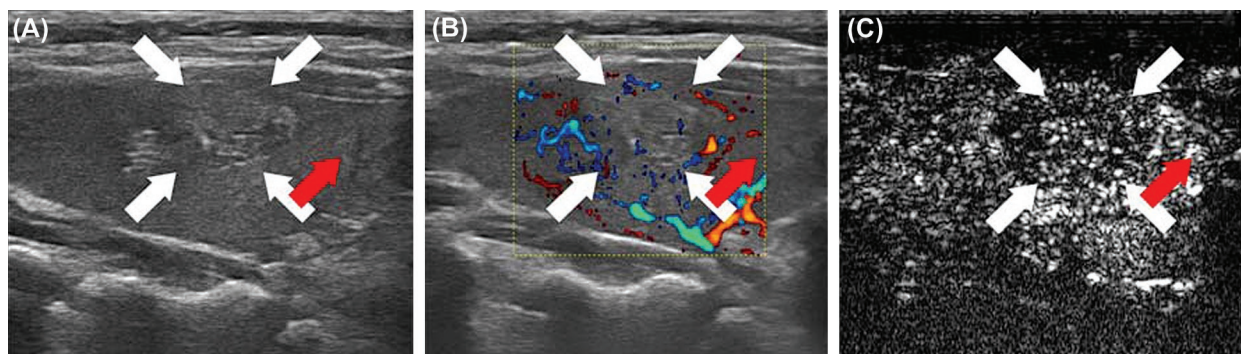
Typical appearance of a malignant nodule (papillary carcinoma): (A) HRUS; (B) Color Doppler; (C) CEUS. The white arrows indicate the lesion. The red arrow indicates a portion of healthy thyroid parenchyma.
